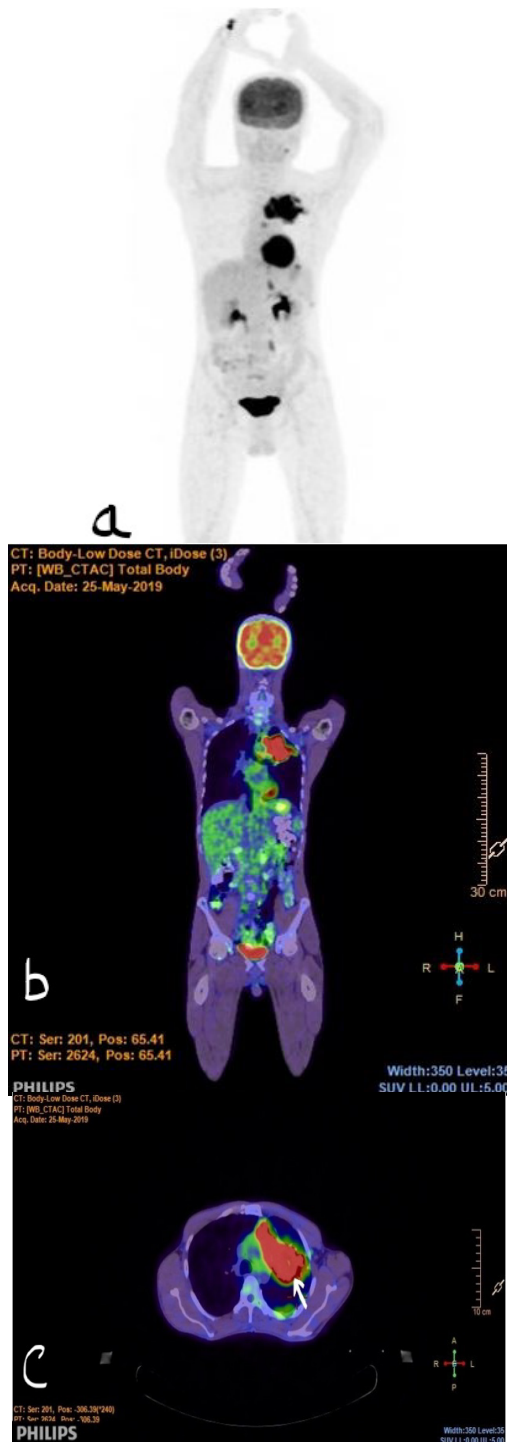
Positron Emission Tomography (PET-CT) scan image of this Case patient
